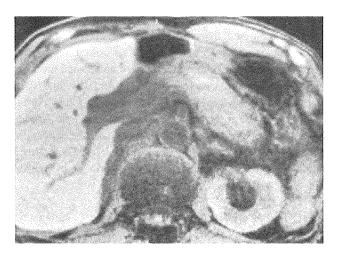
T1-weighted MRI images of the pancreas. Swollen pancreas in the tail shows a lower signal than the liver
